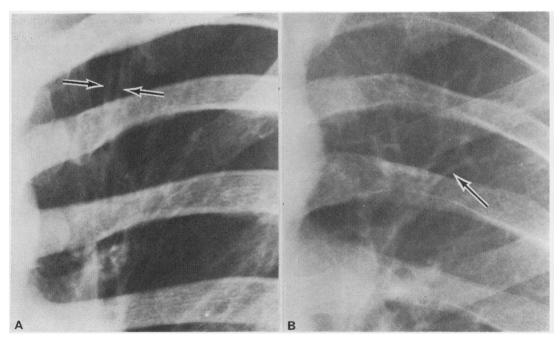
Radiographs of two different patients showing tubular shadows. The arrows point to both walls of a tubular shadow in (A) and to one wall in (B).
